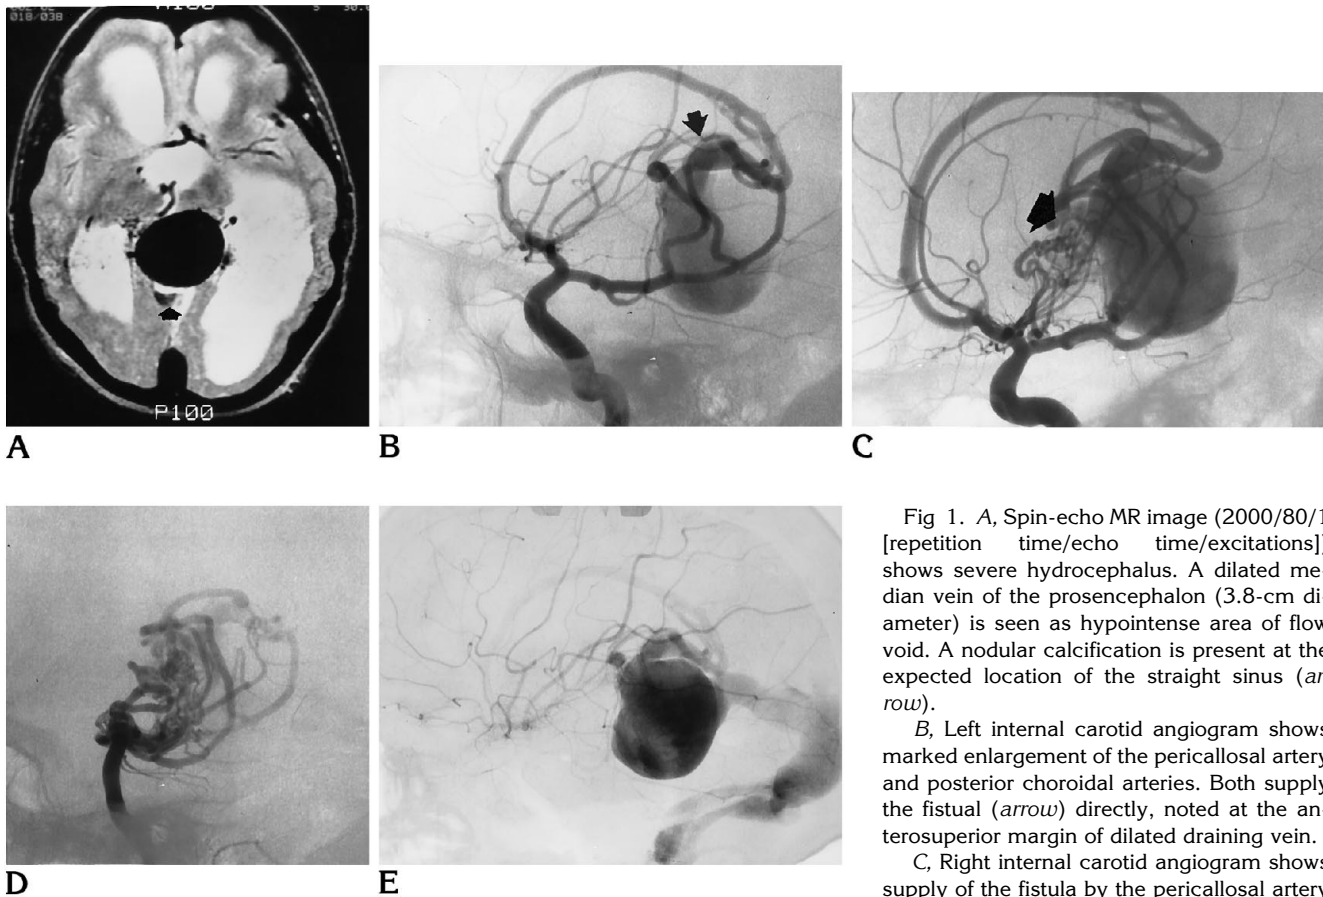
A, Spin-echo MR image (2000/80/1 [repetition time/echo time/excitations]) shows severe hydrocephalus. A dilated median vein of the prosencephalon (3.8-cm diameter) is seen as hypointense area of flow void. A nodular calcification is present at the expected location of the straight sinus (*arrow*).
